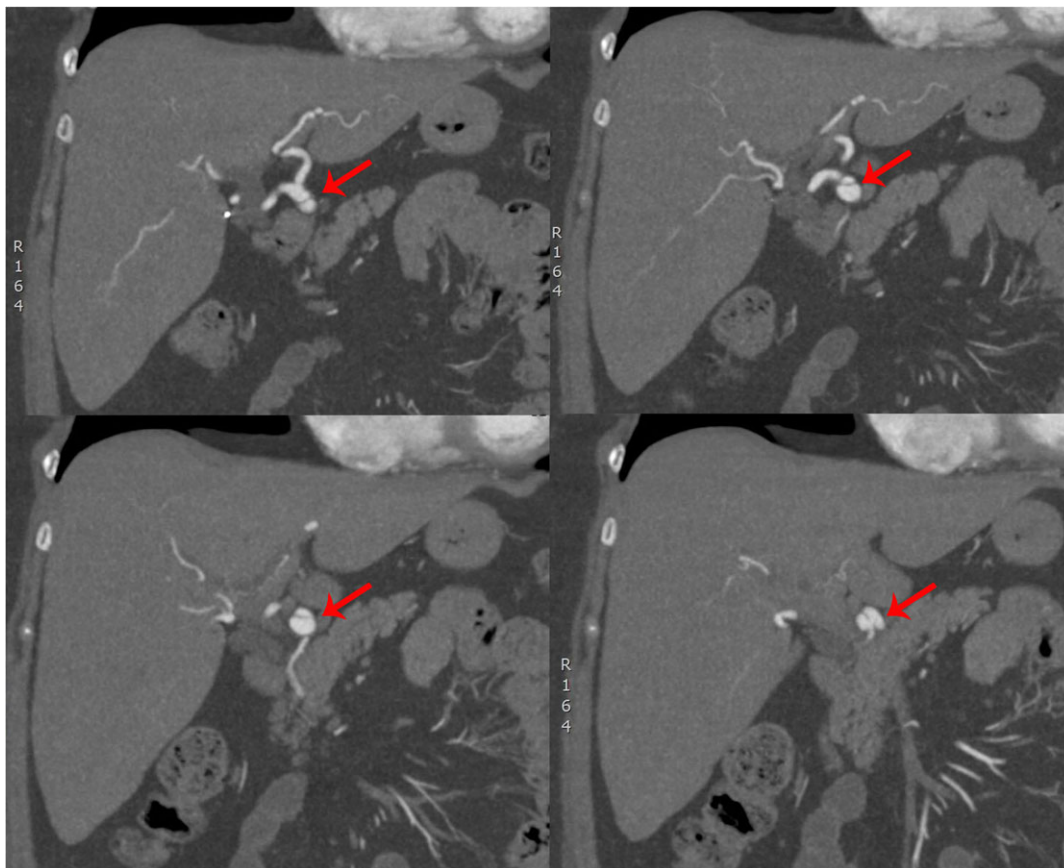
Image series of CT angiography revealing an intimal flap (arrows) demonstrating isolated dissection of the common HA proximal to the bifurcation of the HA.
